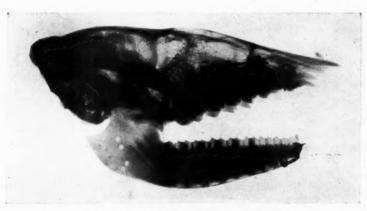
Radiograph of skull of armadilla.
